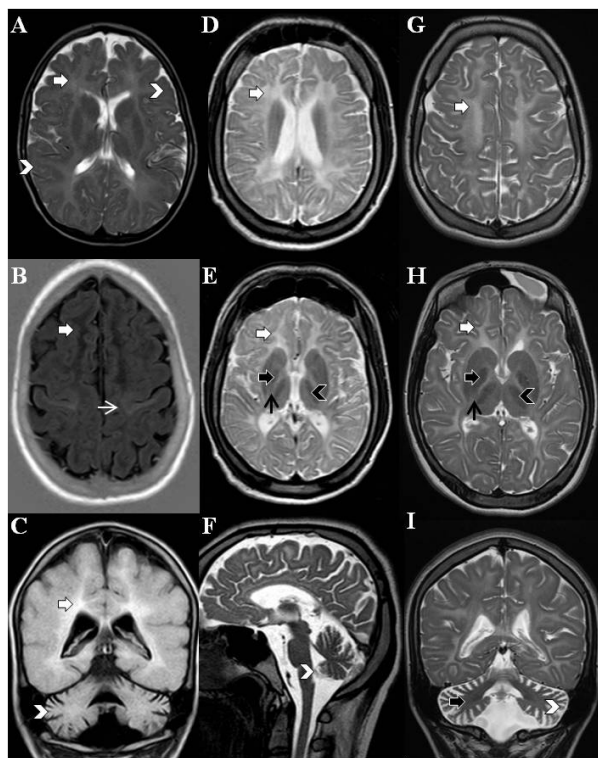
CNS MRI of P1, P2, P3 and P4. Diffuse hypomyelination (white arrows) visible as white matter T2-weight or FLAIR (A, C, D, G, E, H) hyperintensity and T1-weight hypointensity (B) is documented in P1 (B), P2 (A, C), P3 (D, E, F) and P4 (G, H, I). Mildly asymmetric gyrfication compatible with the diagnosis of nonlissencephalic cortical dysplasia with polymicrogyria (A; white arrowheads) is depicted in P2. Cerebellar atrophy, affecting both vermis and the hemispheres, can be observed in FLAIR (C; white arrowheads) and T2-weight sequences (F, I; white arrowheads). T2-weight hypointensity in the area of nucleus dentatus (I; black arrow) can be observed in P4. T2-weight hypointensities in globi pallidi (E, H; black arrows), ventrolateral thalami (E, H; black arrowheads) and the corticospinal tract at the level of the posterior limb of the internal capsule (E, H; black thin arrows) are demonstrated in axial images of P3 and P4. Preserved myelination of gyrus praecentralis and of the corticospinal tract upstream of internal capsule (B; white thin arrow) corresponding to T1-weight hyperintensity is observed in P1.
